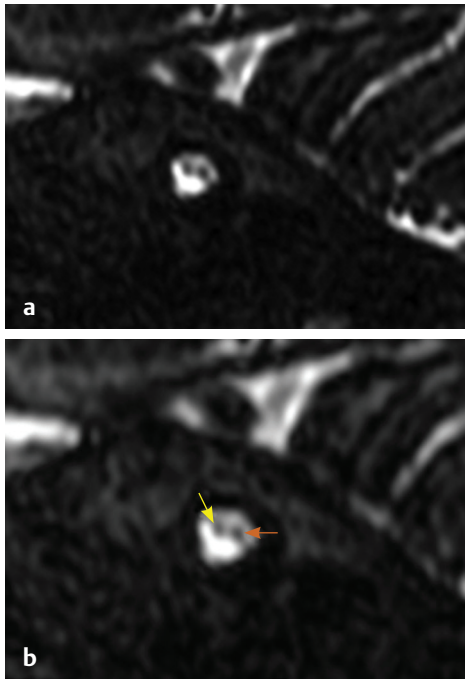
(a) MRI CISS/FIESTA sequence, oblique sagittal reformation images at fundus of internal acoustic canal and (b) show vestibulocochlear nerve (brown arrow) smaller than facial nerve (yellow arrow).
